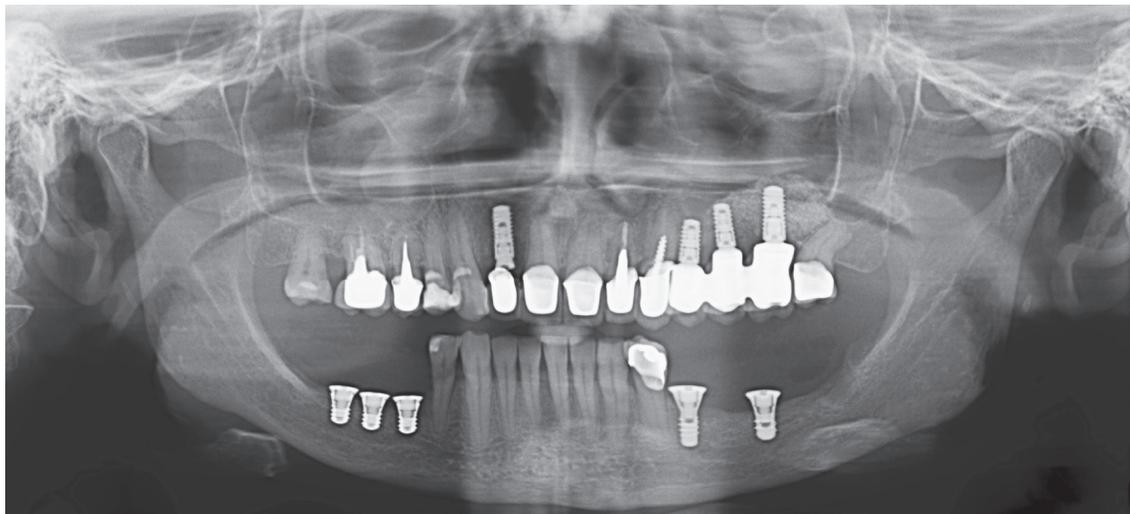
Panoramic radiograph six weeks after surgery revealing placement of extrashort implants on #45, #46 and #47, short implant on #35 and extrashort implant on #37.
